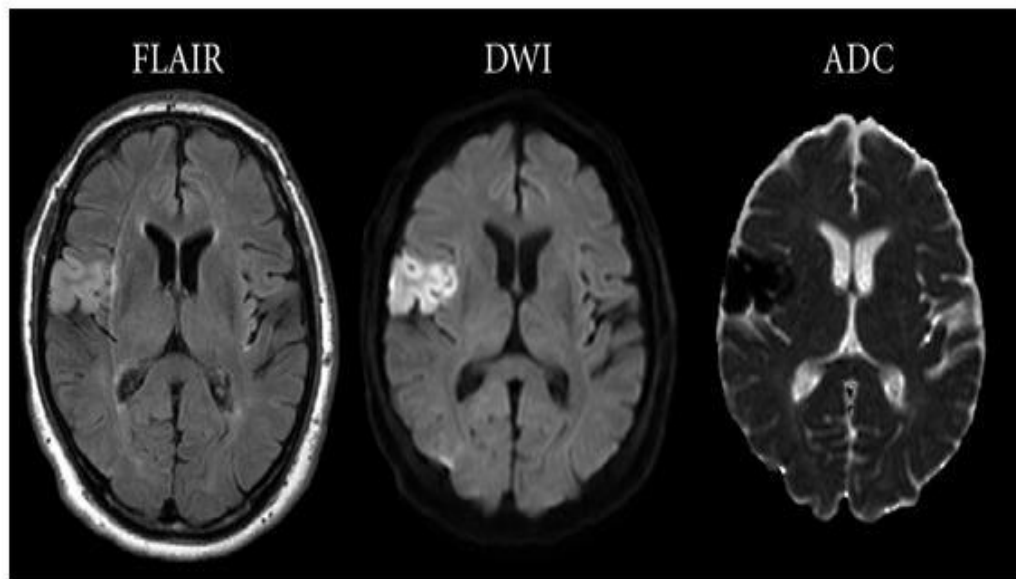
MRI with diffusion scan showing right fronto parietal hyperintensity
